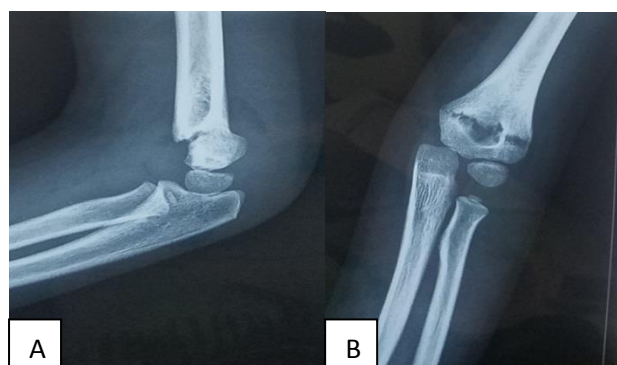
Radiograph of the elbow showing Gartland type II fracture. (A) Lateral view, (B) anteroposterior view.
